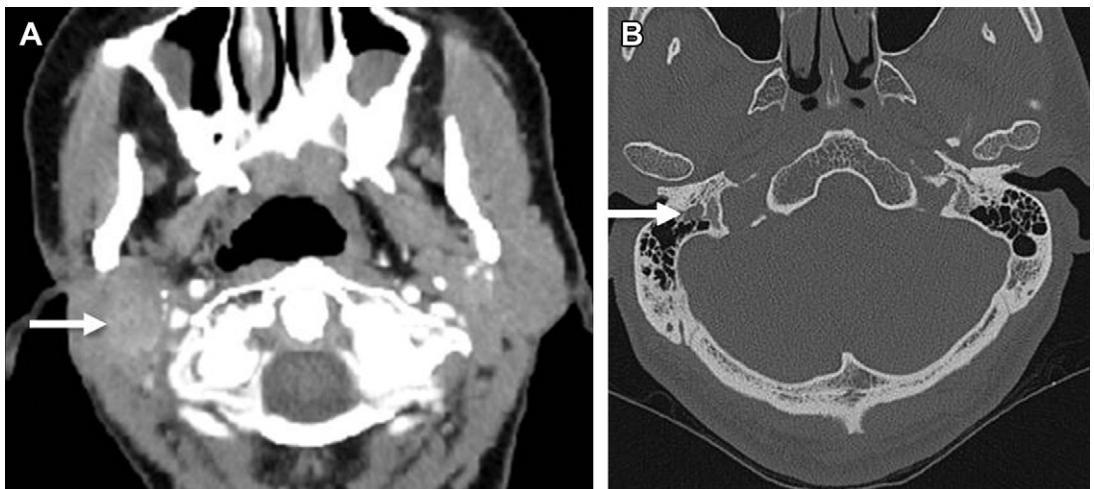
Poorly differentiated carcinoma of parotid gland, T4a from facial nerve involvement. (A) Axial contrast-enhanced CT shows a 2-cm mass (*arrow*) in the right parotid gland with ill-defined margins. (B) Bone windows demonstrate enlargement of the right facial nerve canal mastoid segment (*arrow*).
